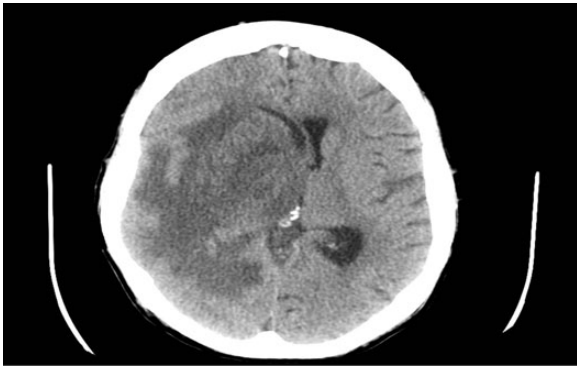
CT head with and without contrast showing an ill-defined hypodensity at the right medial temporal lobe causing mass effect and uncal herniation with surrounding vasogenic edema. Abbreviation: CT, computerized tomography.
